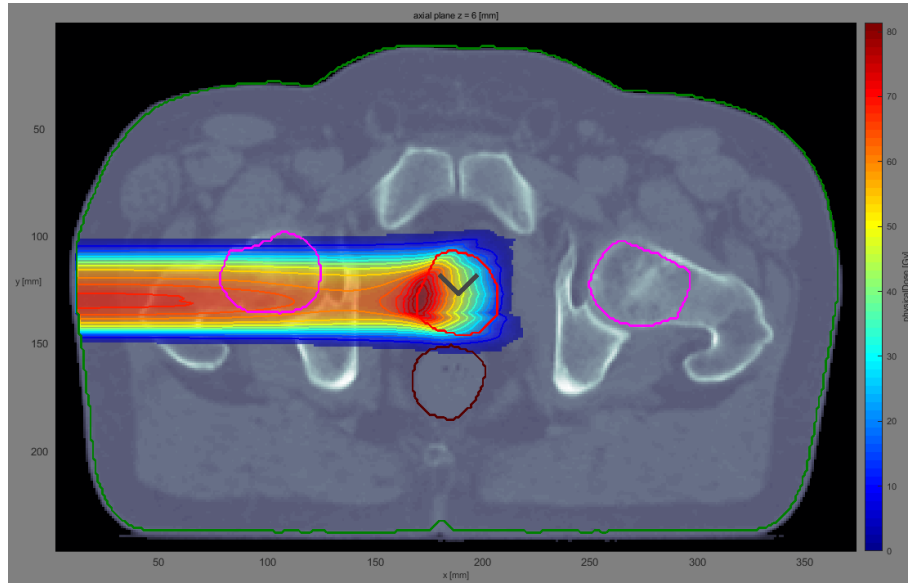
Dose distribution for given prostate CT dataset with objective of achieving a mean dose of 50 Gy. A candidate CTV (prostate) is highlighted in red, along with potential OARs (femoral heads and rectum) in pink and dark red.
